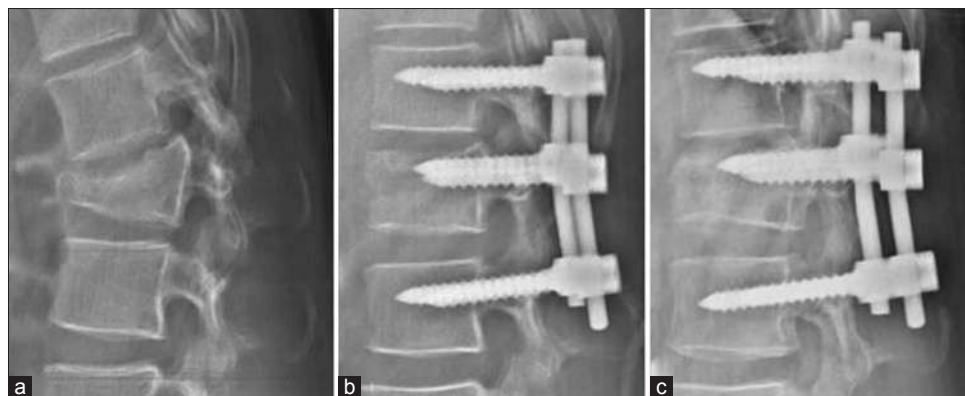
X-ray thoracolumbar spine lateral view showing (a) L1 flexion-distraction injury (b) treatment with posterior short segment fixation and intermediate screws (c) Lateral radiograph performed at the end of 1-year shows good fracture healing
